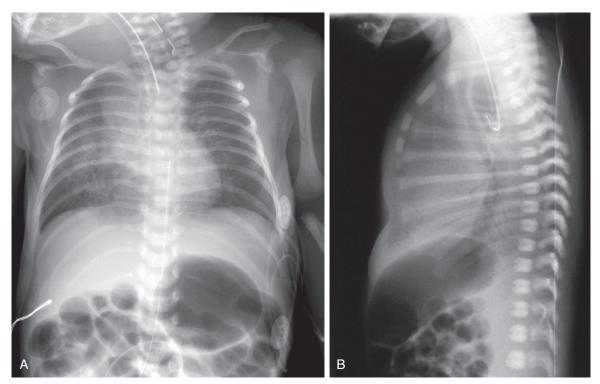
Tracheoesophageal fistula. A, Anteroposterior chest radiograph shows feeding tube passing no farther than proximal esophagus; there is an aspiration pneumonitis present. B, Lateral view showing the feeding tube in the proximal esophageal pouch with air in the airway, distal esophagus, and intestine. (A, Courtesy Beverly Newman, MD, Pittsburgh, Pa; B, courtesy Katie McPeak, MD, Pittsburgh, Pa.)
